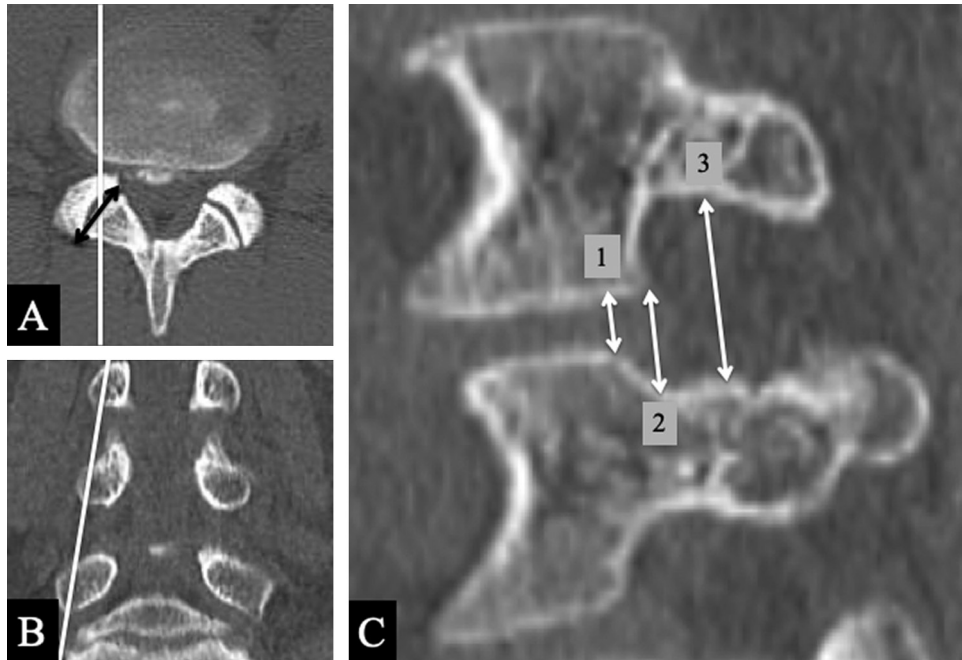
Reconstructed axial (A), coronal (B), and sagittal (C) CT images of the lumbar spine. The heights of the intervertebral disc (C-1), the bulging disc (C-2), and the intervertebral foramen (C-3) were measured on a sagittal slice. CT: computed tomography.
